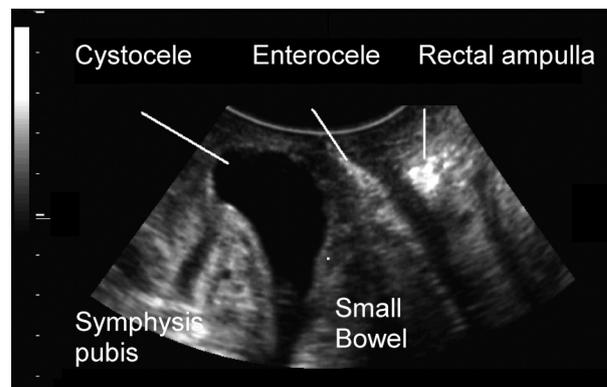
Translabial ultrasound with convex probe, showing multicompartimental pelvic organs prolapse.
